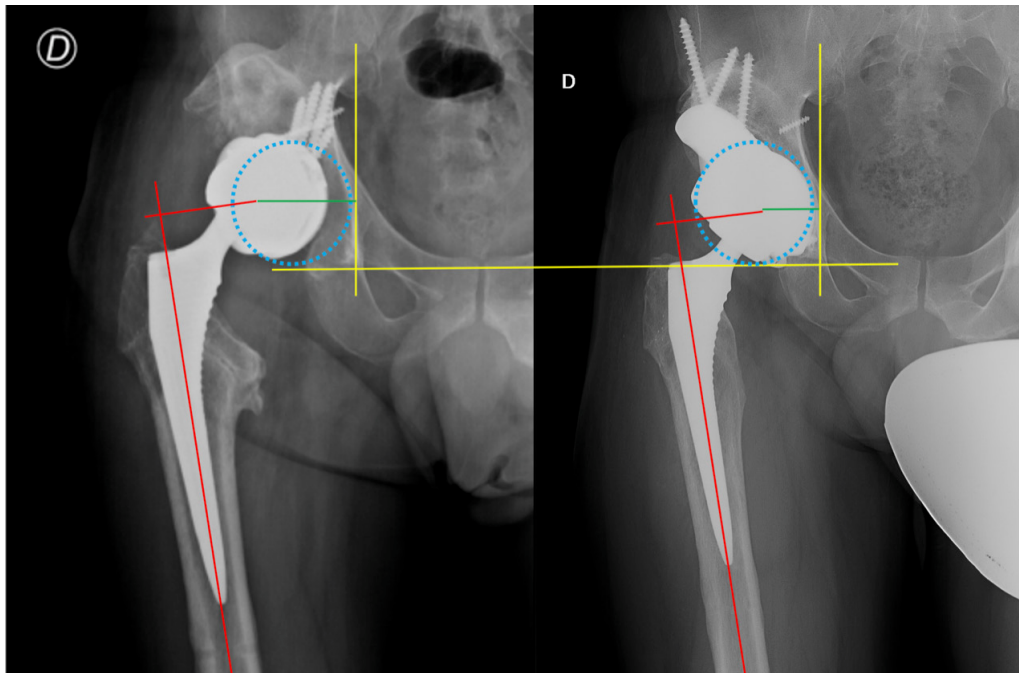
Pre-operative and 39 months follow-up x-rays of custom implant: biomechanical parameters are restored.
